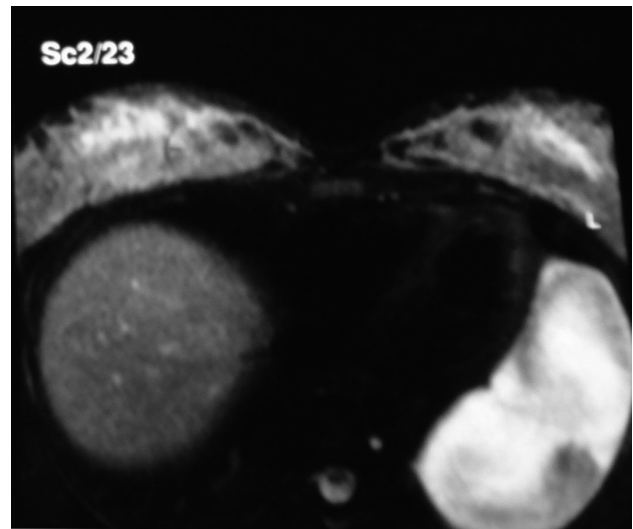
MRI exam of pulmonic basis and abdomen (transverse scan): lightly lobulated, thick liquid collection with diameter about 106 mm in suprabasal and basal pericardial part of left hemithorax.
